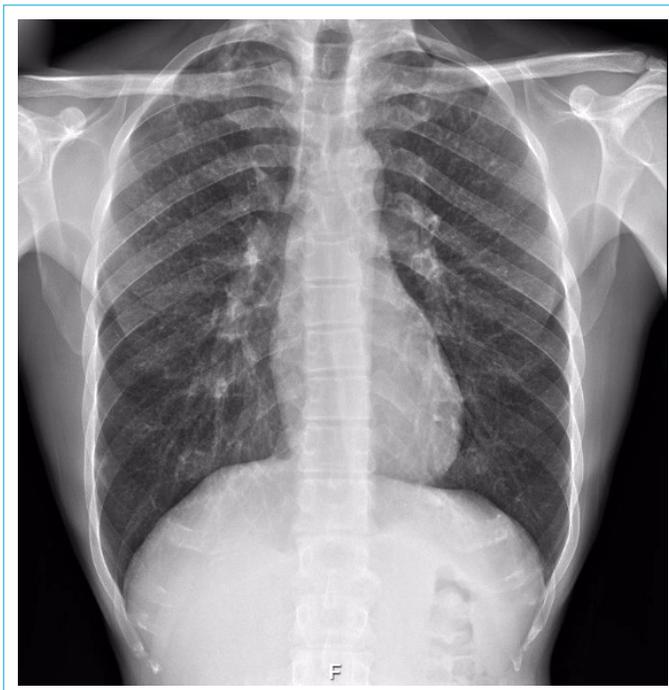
Diffuse nodular opacity was seen on chest x-ray.
